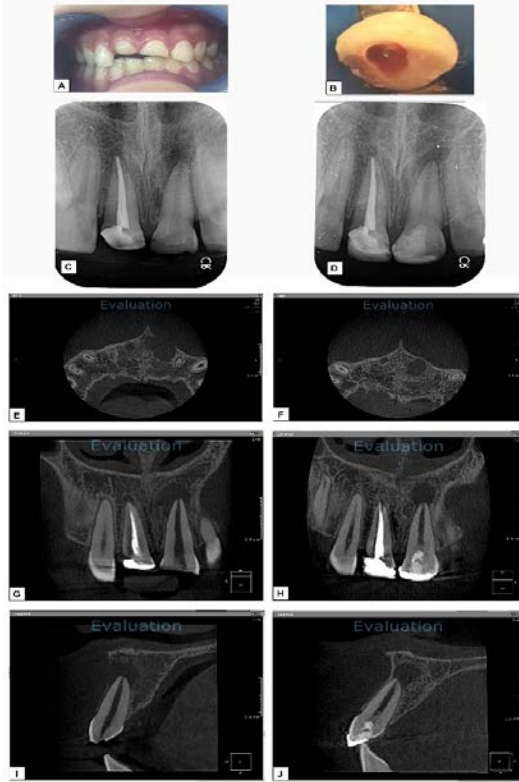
Case #3 tooth #9. A: Preoperative photograph, B: Intraoperative photograph showing induction of bleeding, C: Preoperative periapical radiograph, D: After twelve months follow up periapical radiograph showing incomplete resolution of the lesion, E,G,I: Preoperative CBCT showing the lesion in axial, coronal and sagittal planes respectively, F,H,J: After twelve months follow up CBCT in axial, coronal and sagittal planes showing incomplete resolution of the lesion, H,J: Coronal and sagittal planes showing narrowing of the apical diameter.
